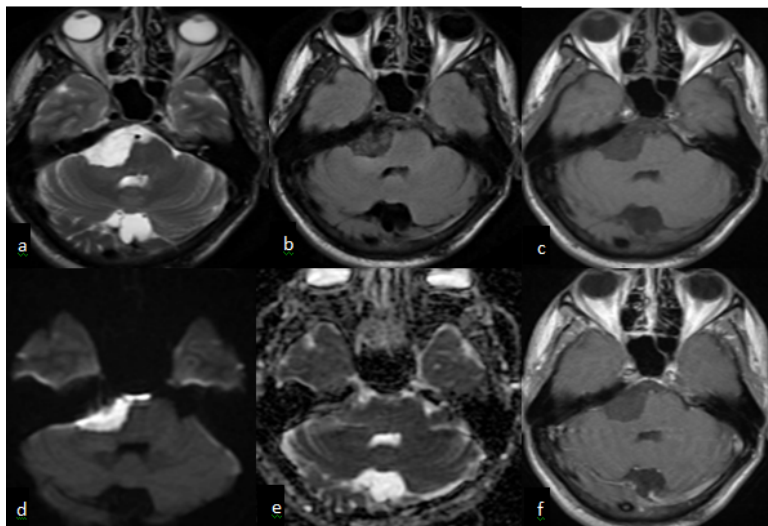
Epidermoid cyst of right cerebellopontine angle. (a) Axial T2-weighted imaging showed hyperintense lesion occupying the right cerebellopontine angle. The lesion causing mild mass effect over right side of pons (b) It is hypointense with dirty signal on FLAIR imaging and (c) hypointense on T1 weighted image (d,e) it showed restriction on diffusion weighted imaging, (f) Axial post-contrast T1-weighted image shows no post contrast enhancement
